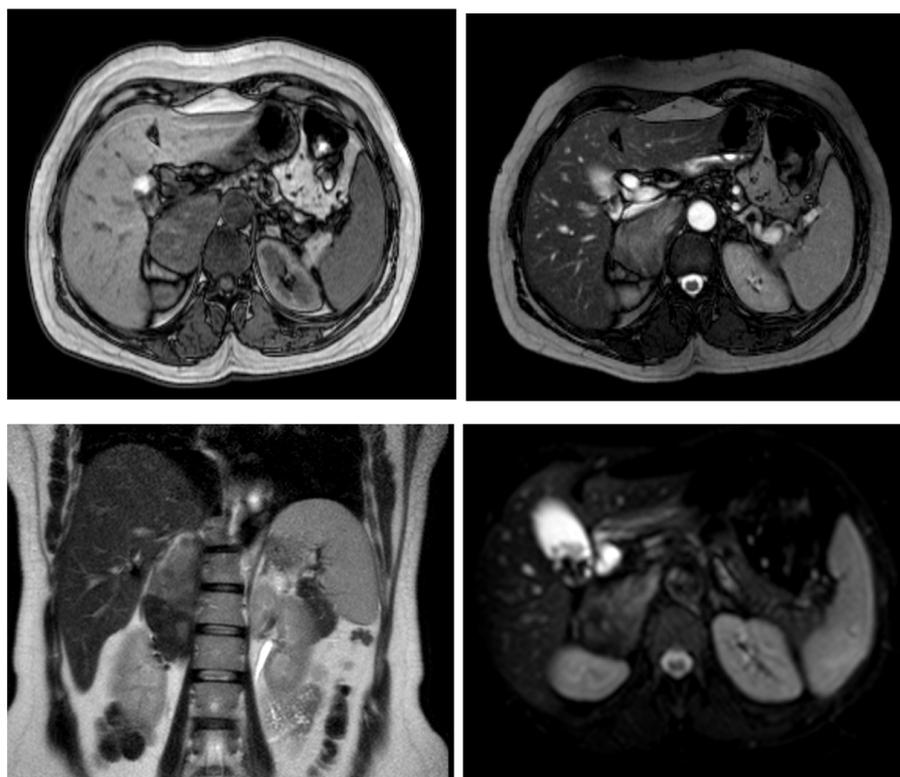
Mass lesion is in the right adrenal region on MR imaging
